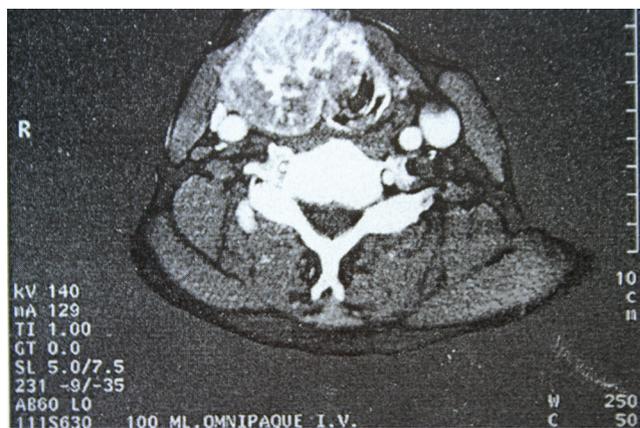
CT scan of laryngeal chondrosarcoma.
